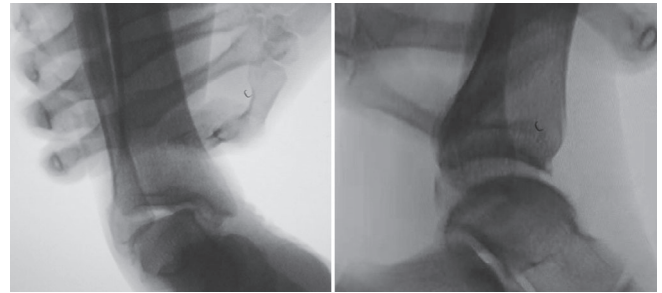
The measurement of talar tilt angle (TTA) and anterior talar translation (ATT) in stress radiography with one hand immobilizing the crus and the other hand using the spring dynamometer to pull the foot with gauze.
